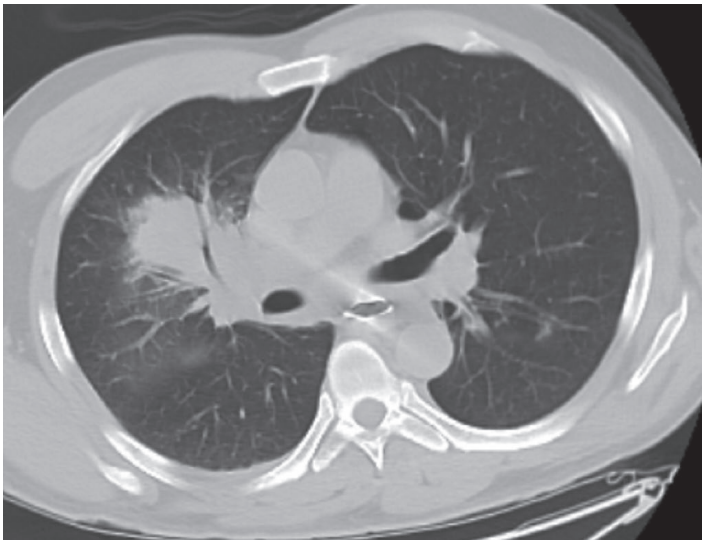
Axial computed tomography (CT) of the chest 13 months ago showed dense bronchocentric right upper lobe consolidation and right hilar lymphadenopathy.
